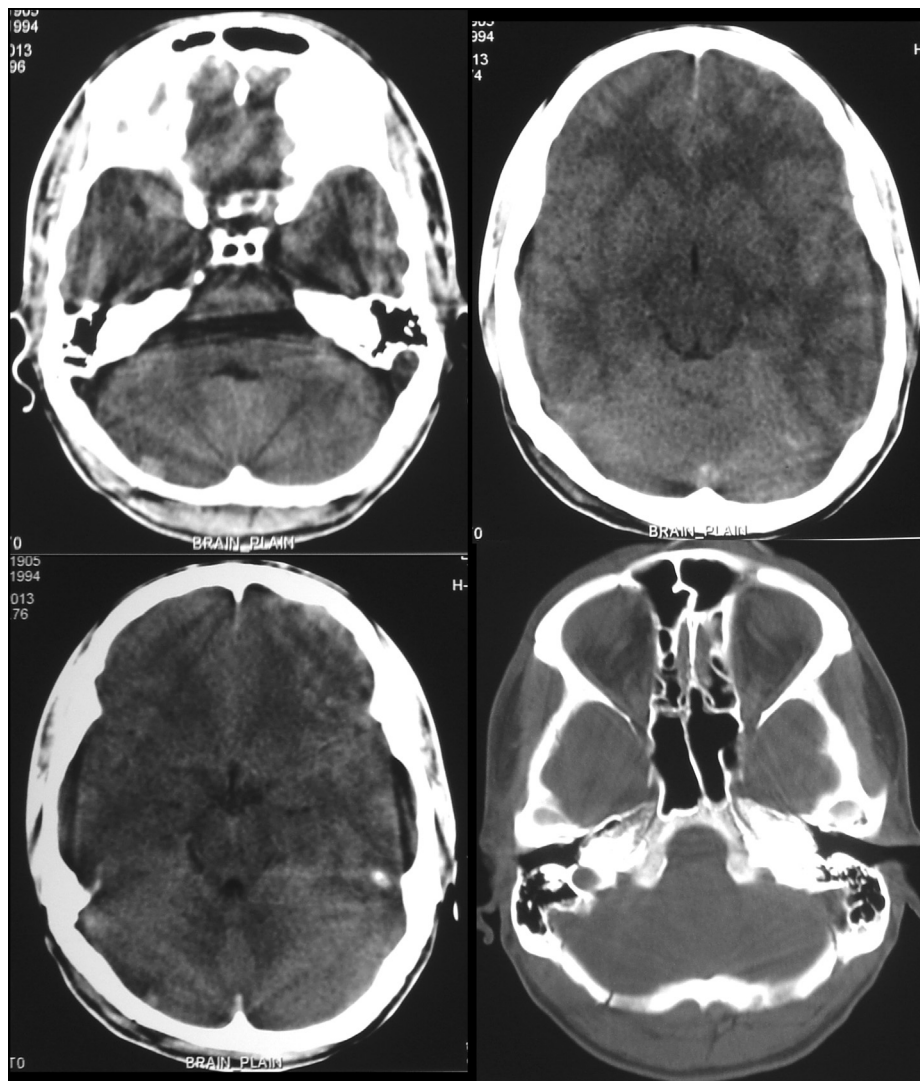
CT scan brain 4 h after injury showing only mild cerebral edema, small right cerebellar contusion, patchy left frontal basal contusion and right occipital bone linear fracture.
